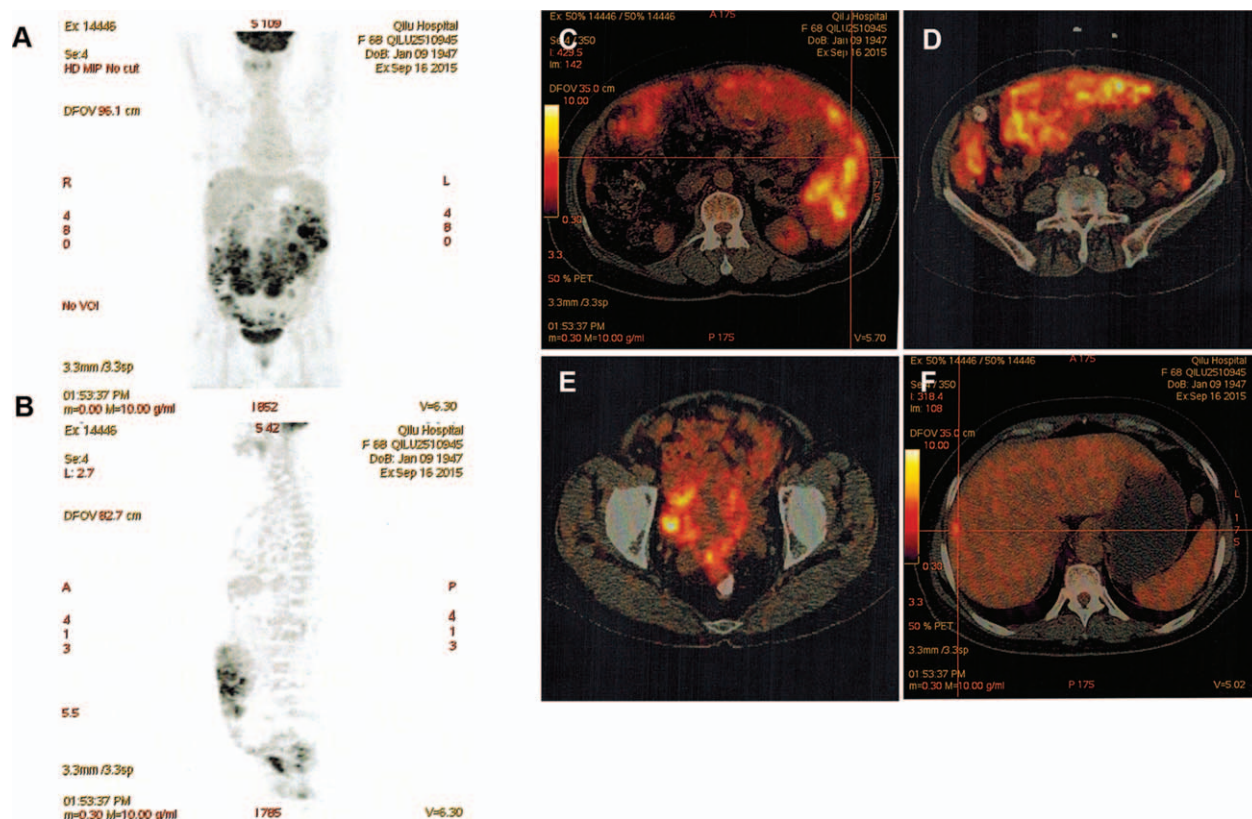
Maximum intensity projection images (A and B) and positron emission tomography/computed tomography fusion images (C, D, E, and F) show heterogeneous fluorodeoxyglucose (FDG) uptake in multiple abdominal and pelvic masses. Maximum standardized uptake value (SUV_{max}) of the masses is 12.1.
